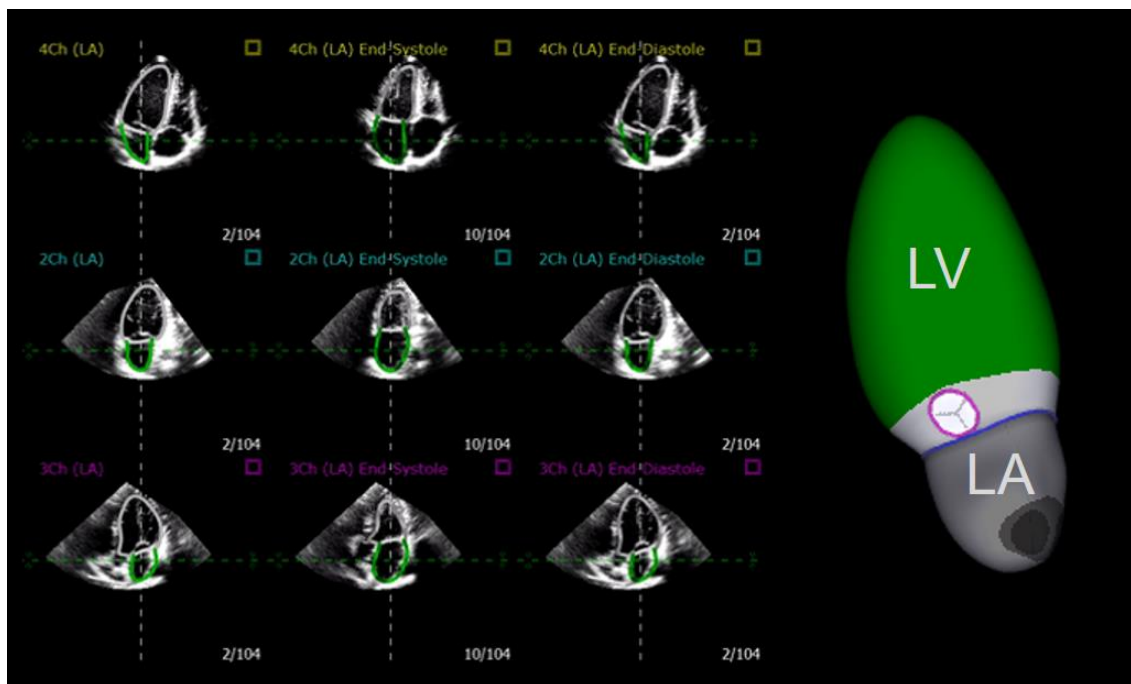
Three-dimensional echocardiographic analysis of the left atrium (LA) and the left ventricle (LV). Following the correction of the LV and LA long axis, the algorithm detects the endocardial borders and traces their motion throughout the cardiac cycle in multiple planes, also allowing manual editing if needed. Therefore, 3D models of the LA
